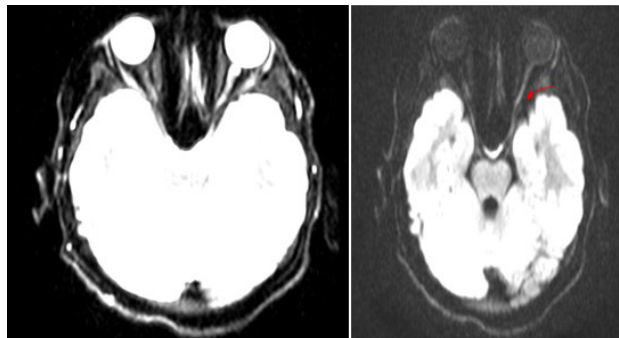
MRI brain with contrast (T1) showing contrast enhancement of left optic nerve indicating left optic neuritis.
